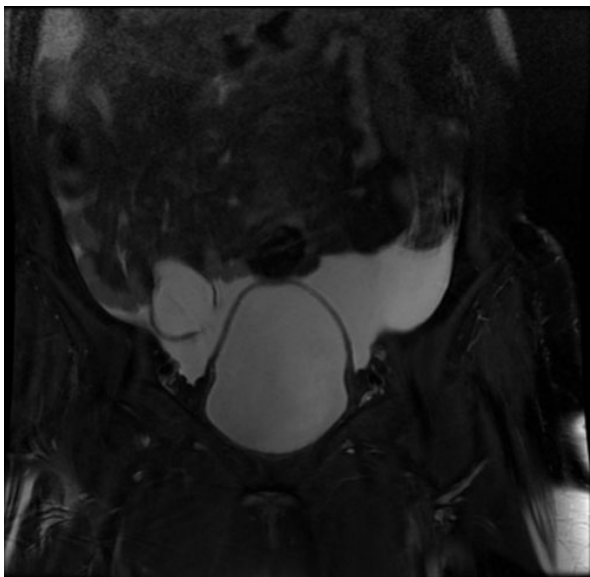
MRI T2-weighted coronal cut with fat suppression showing cystic formation in the right iliac fossa, contiguous to the appendix, thin-walled, and open in the large peritoneal cavity with ascites of moderate abundance.
